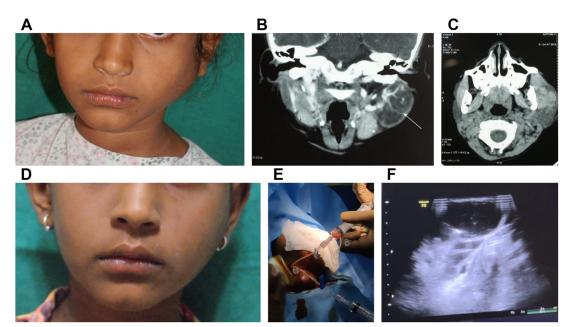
Case 2: Low-flow malformation treated with ultrasound-guided intralesional bleomycin. (*A*) Left lower lateral facial mass with asymmetry. (*B*) Contrast enhanced computed tomography (CT) coronal section with the arrow depicting a left cystic parotid area lesion. (*C*) Contrast enhanced CT axial section with a left parotid lesion with mixed density after intralesional injections. (*D*) Left lower lateral facial mass resolved post therapy as noted in case 2 and injections demonstrated in Fig. 2E and F. (*E*) Intralesional injection with due aspiration and direct injection. (*F*) Ultrasound-guided injection of bleomycin.
